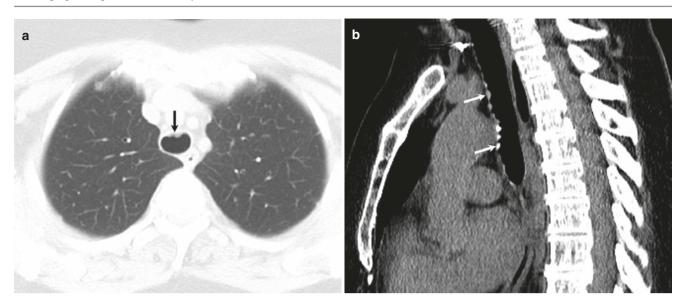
Tracheobronchopathia osteochondroplastica. (a) Axial CT image shows luminal nodules (arrow) in the anterior wall of the trachea. (b) Sagittal CT image shows a chain of calcified and noncalcified nodules (arrows) in the anterior wall of the trachea
